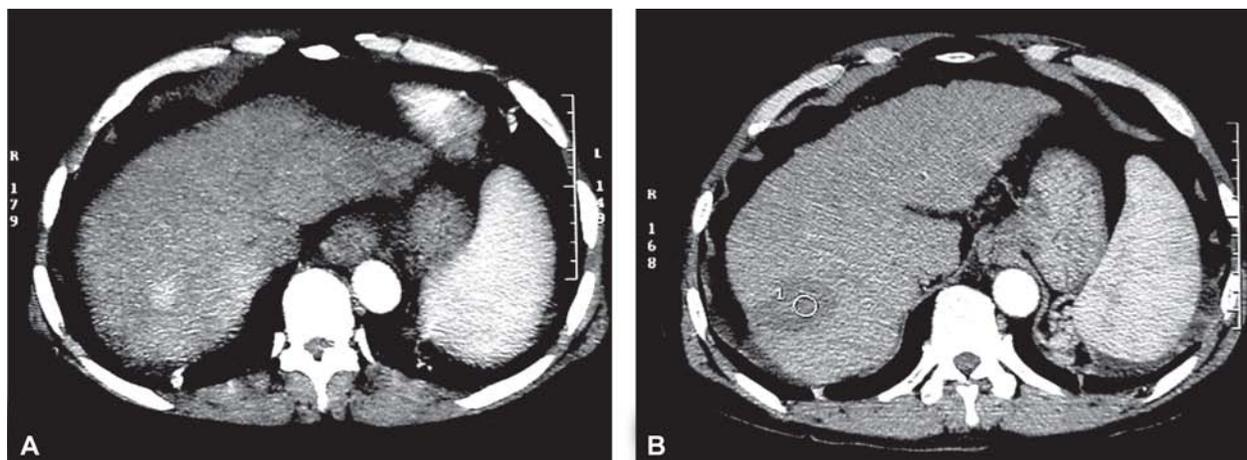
CT-before and after RFA (minor response)
